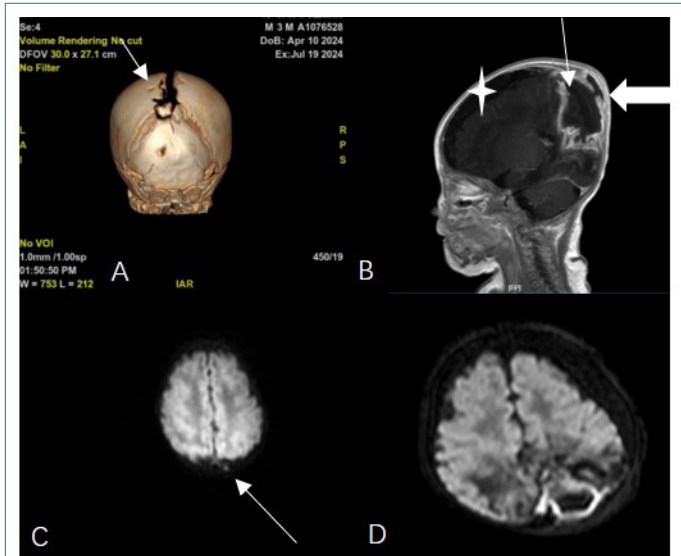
Preoperative imaging examination for brain abscess. (A) Preoperative cranial CT showing parietal bone defect. (B) Preoperative enhanced MRI: T1-weighted image showing extracranial soft tissue mass, adjacent intracranial cystic lesion (thin arrow), rim enhancement, inferior parietal bone destruction (thick arrow), brain abscess and subdural effusion (asterisk). (C) DWI of cranial MRI at 1 month after birth showing high signal in the left parietal intracranial region. (D) Preoperative DWI showing abscess formation.
